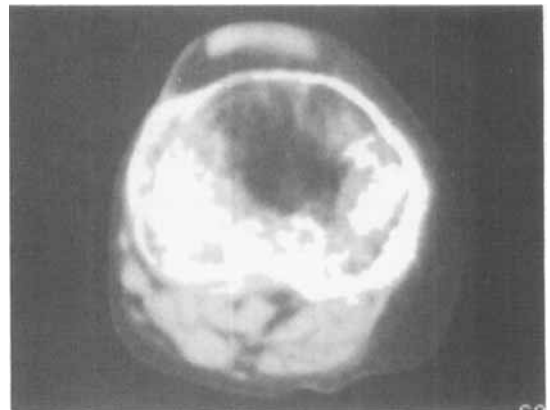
CT slice through the tibial condyle. The pixels used in the computation are highlighted.
